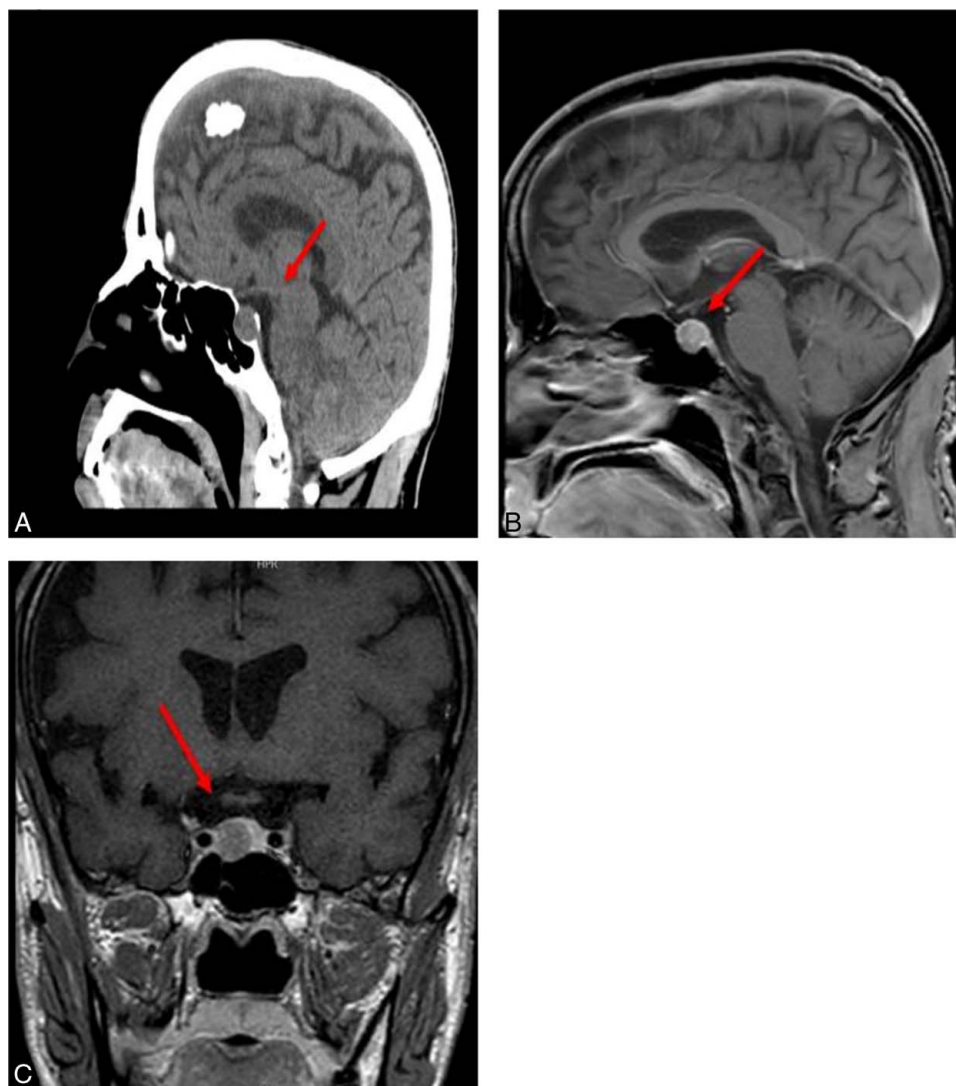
Brain CT without contrast (A) and pituitary MRI (B) and (C) showed a well-defined sellar mass lesion measuring about 1.4×1.35×1.3 cm with relative sellar expansion representing pituitary macroadenoma. CT, computed tomography.
